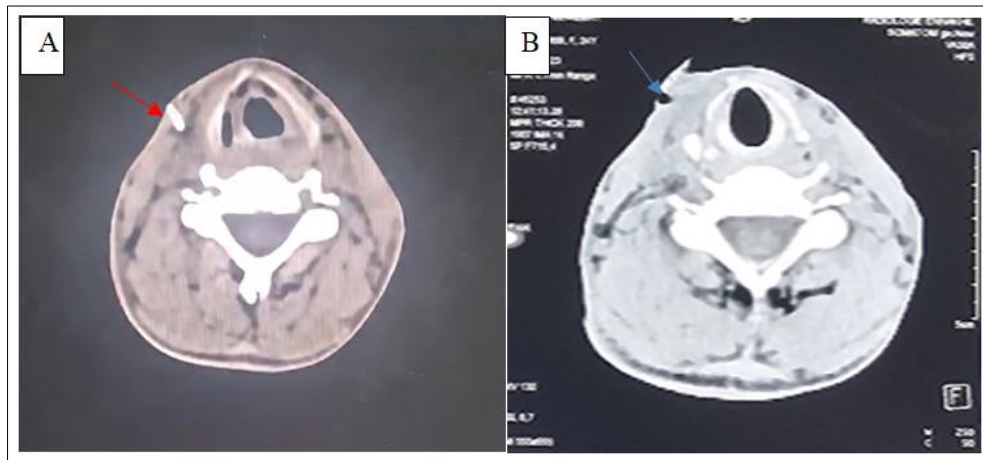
A: Axial-section CT scan showing the foreign body (red arrow). B: Axial section CT scan showing the loss of substance surrounding the foreign body (blue arrow)
